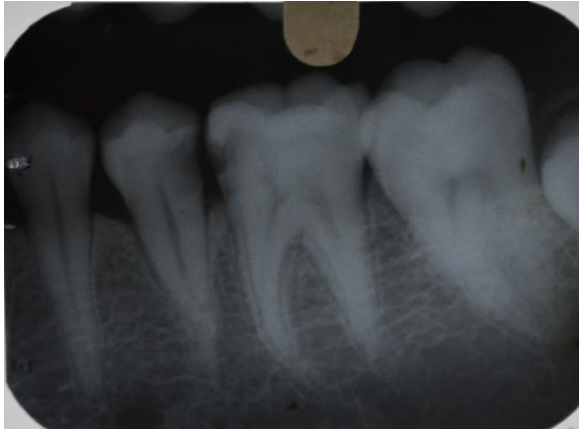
Diagnostic radiograph with tooth #35.
